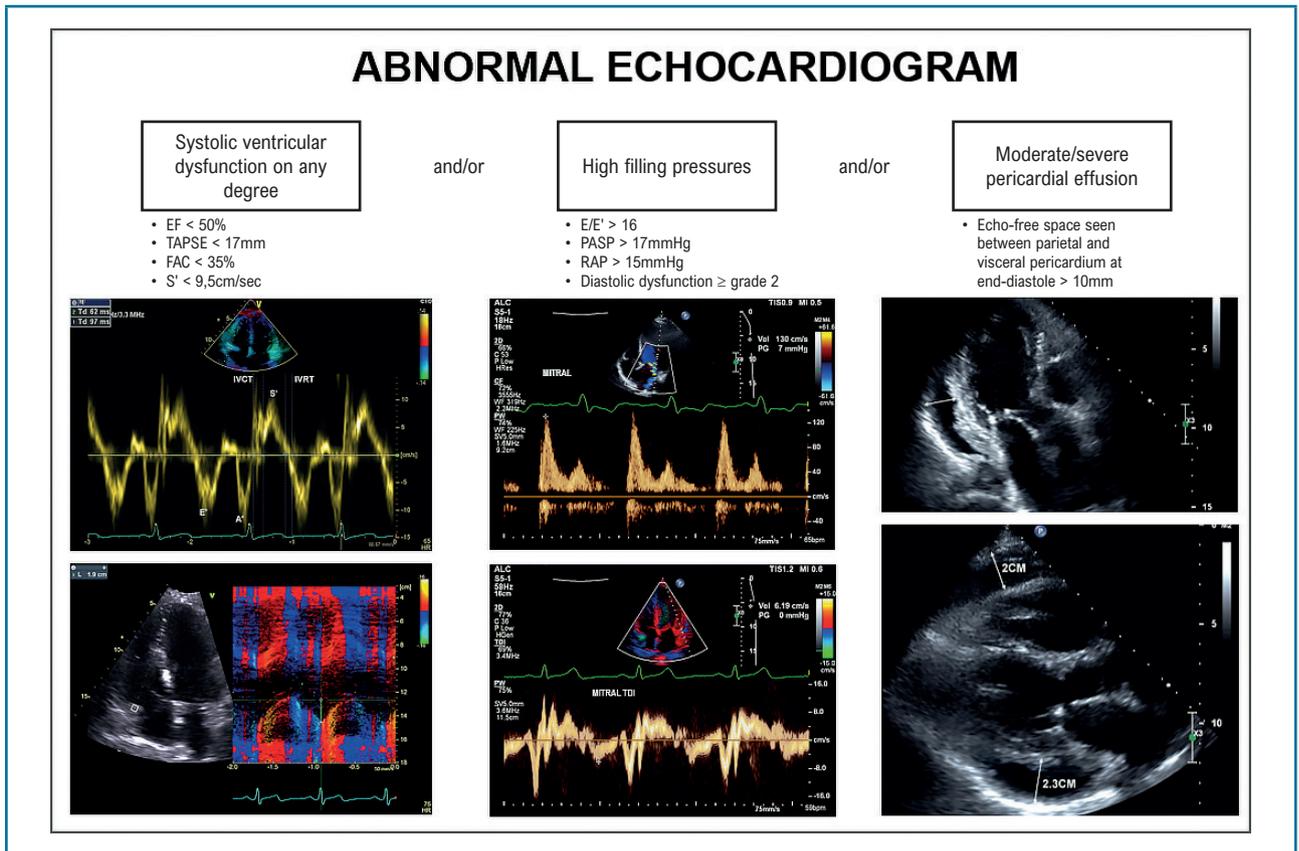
Criteria for abnormal echocardiogram.
